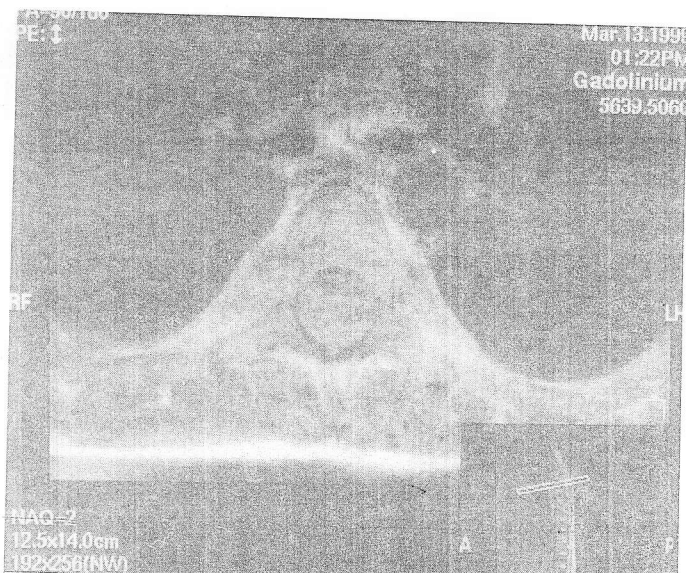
Post-contrast T1-weighted MRI (axial section) showing the homogeneously enhanced lesion causing spinal cord compression and the cord is flattened anteriorly.
